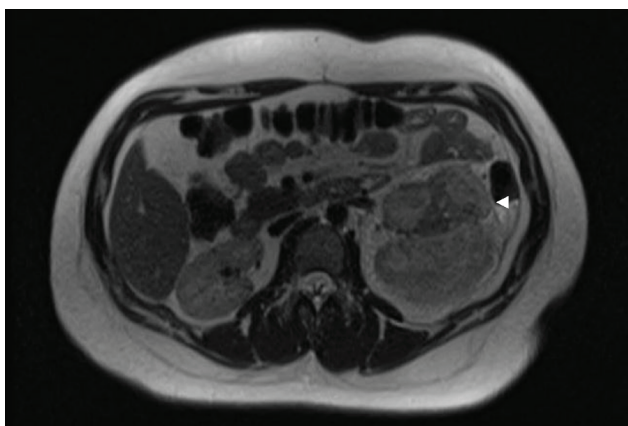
MRI of the upper abdomen showing a heterogeneous mass in the left kidney (*arrowhead*).
